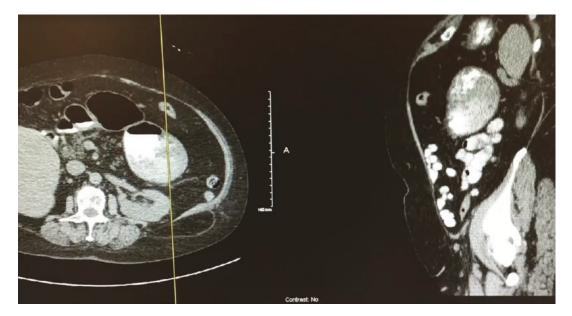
Typical CT appearance of left-sided lumbar hernia containing preperitoneal fat
